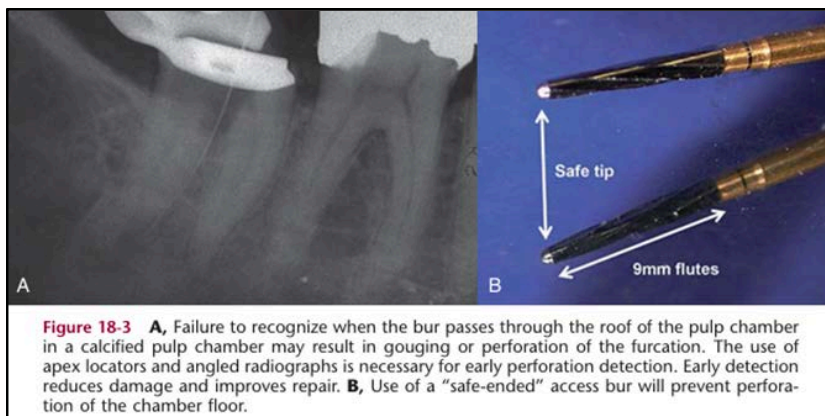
A, Failure to recognize when the bur passes through the roof of the pulp chamber in a calcified pulp chamber may result in gouging or perforation of the furcation. The use of apex locators and angled radiographs is necessary for early perforation detection. Early detection reduces damage and improves repair. B, Use of a "safe-ended" access bur will prevent perforation of the chamber floor.
